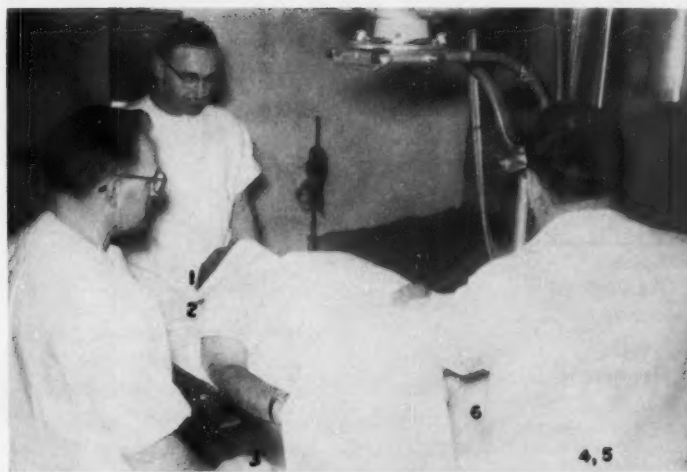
The approximate location of the measurement positions which are given in Figure 1 are indicated on this photograph of the urologist, anesthetist and x-ray technician.
